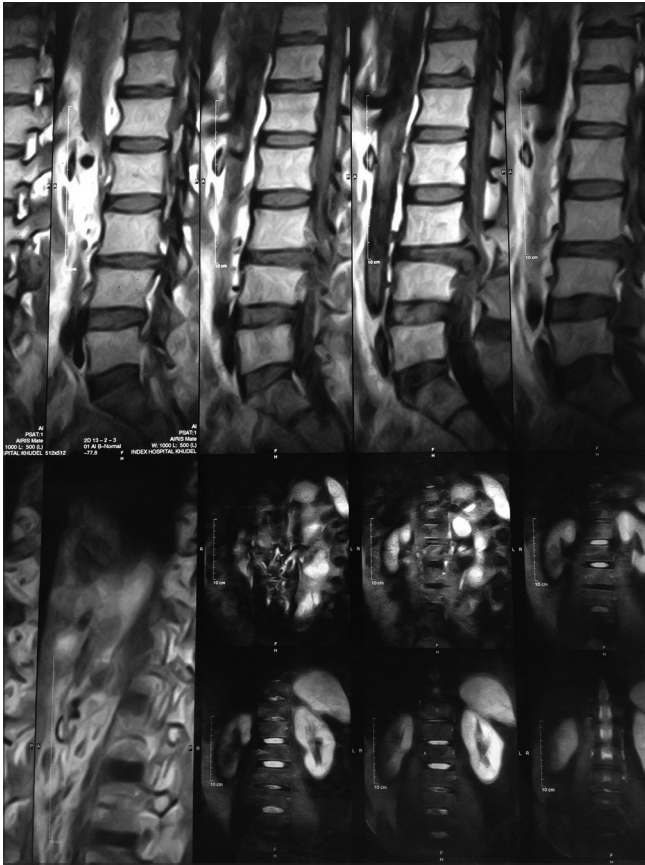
Magnetic resonance imaging of lumbosacral spine of the patient
